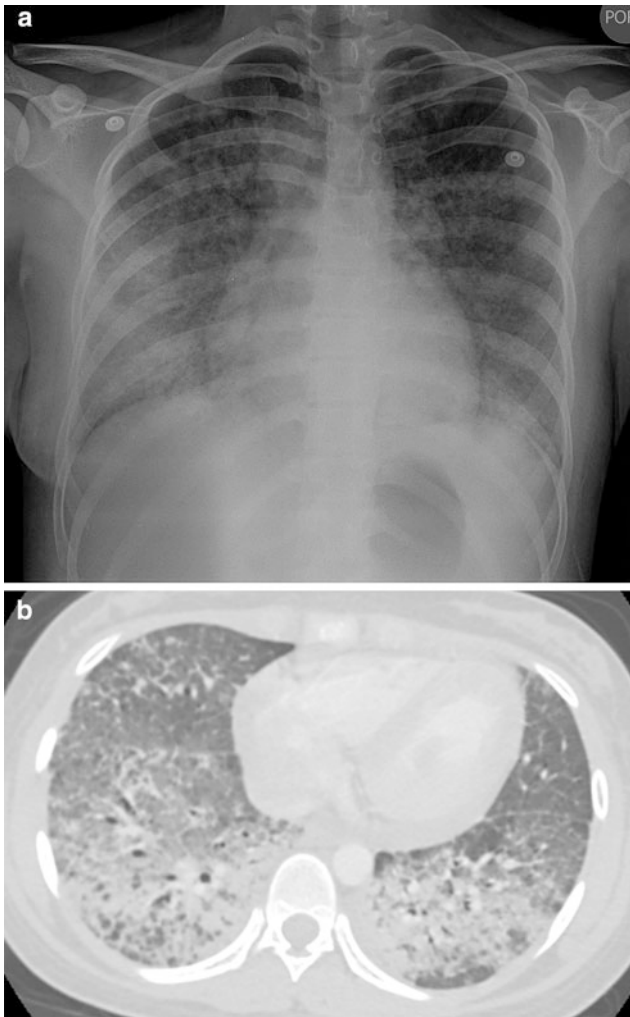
Acute lupus pneumonitis. A frontal CXR (a) and an axial chest CT image (b) depict extensive bilateral pulmonary air space opacification in this 13-year-old girl with SLE and acute respiratory symptoms
